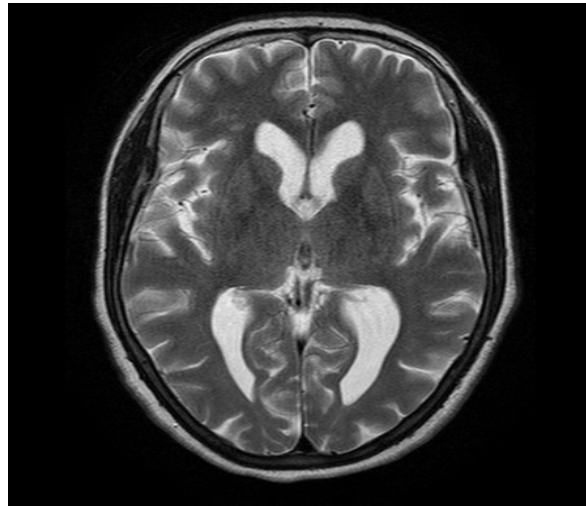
Axial MRI T2 of Lateral ventricle
